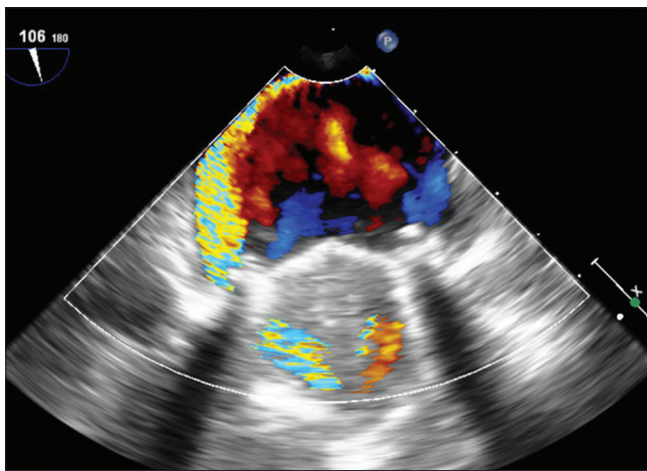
Perioperative transesophageal echocardiography in a patient with paravalvular leak after bileaflet prosthetic mitral valve implantation. Severe medial mitral regurgitation jet
